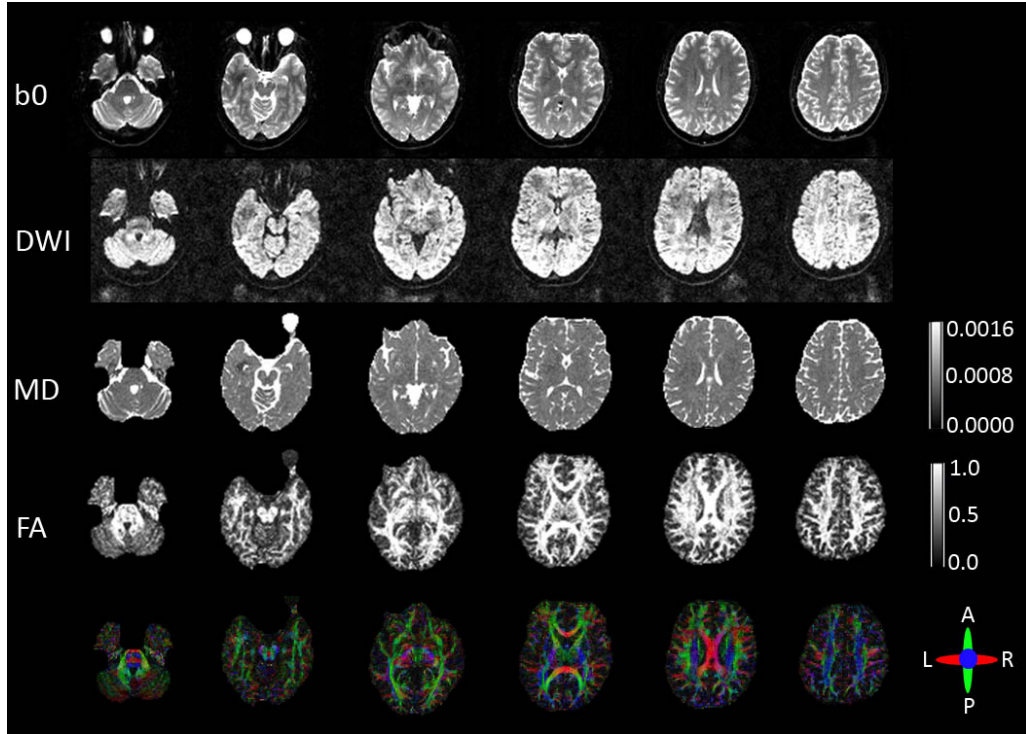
Top to bottom, axial slices of non-diffusion weighted ( $b_0$ ), diffusion weighted images (DWI), mean diffusivity (MD), fractional anisotropy (FA) and colour map of the primary diffusion direction (red = right – left, green = anterior – posterior, blue = inferior – superior) in one healthy control.
